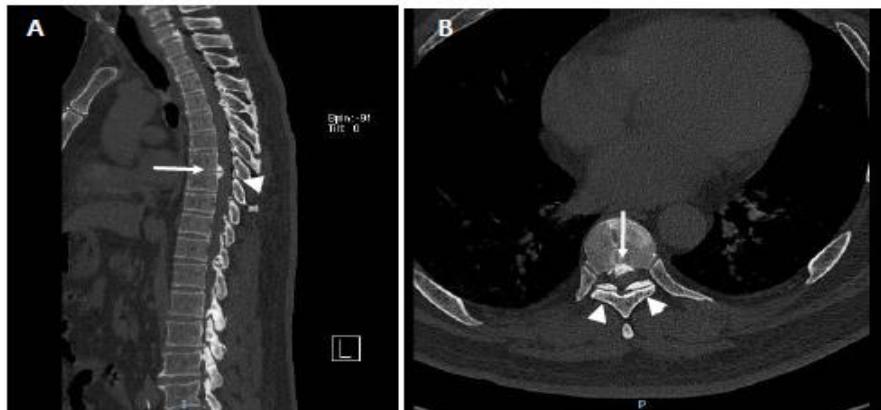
CT scan showed T7-T8 hard disc prolapse for calcified disc osteophytes (arrows) and calcified ligament flavum bilaterally (arrow heads).
